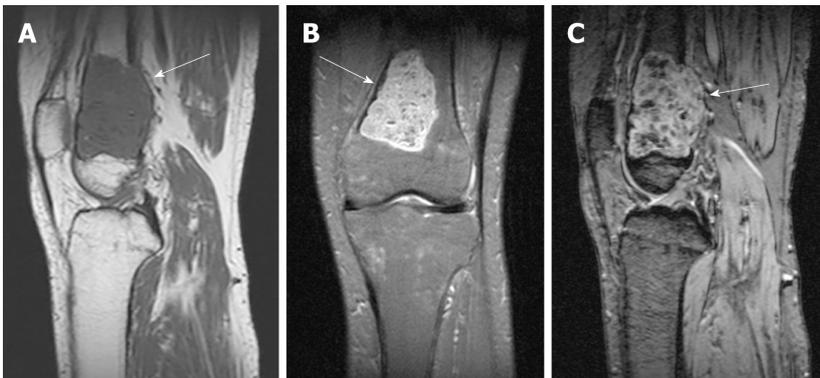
Magnetic resonance imaging of the left knee. A: T1WI sagittal view; B: PDWI coronal view; C: PDWI sagittal view. T1 hypointense (arrow, A) and T2 high-low mixed signal (arrows, B and C) are shown.
